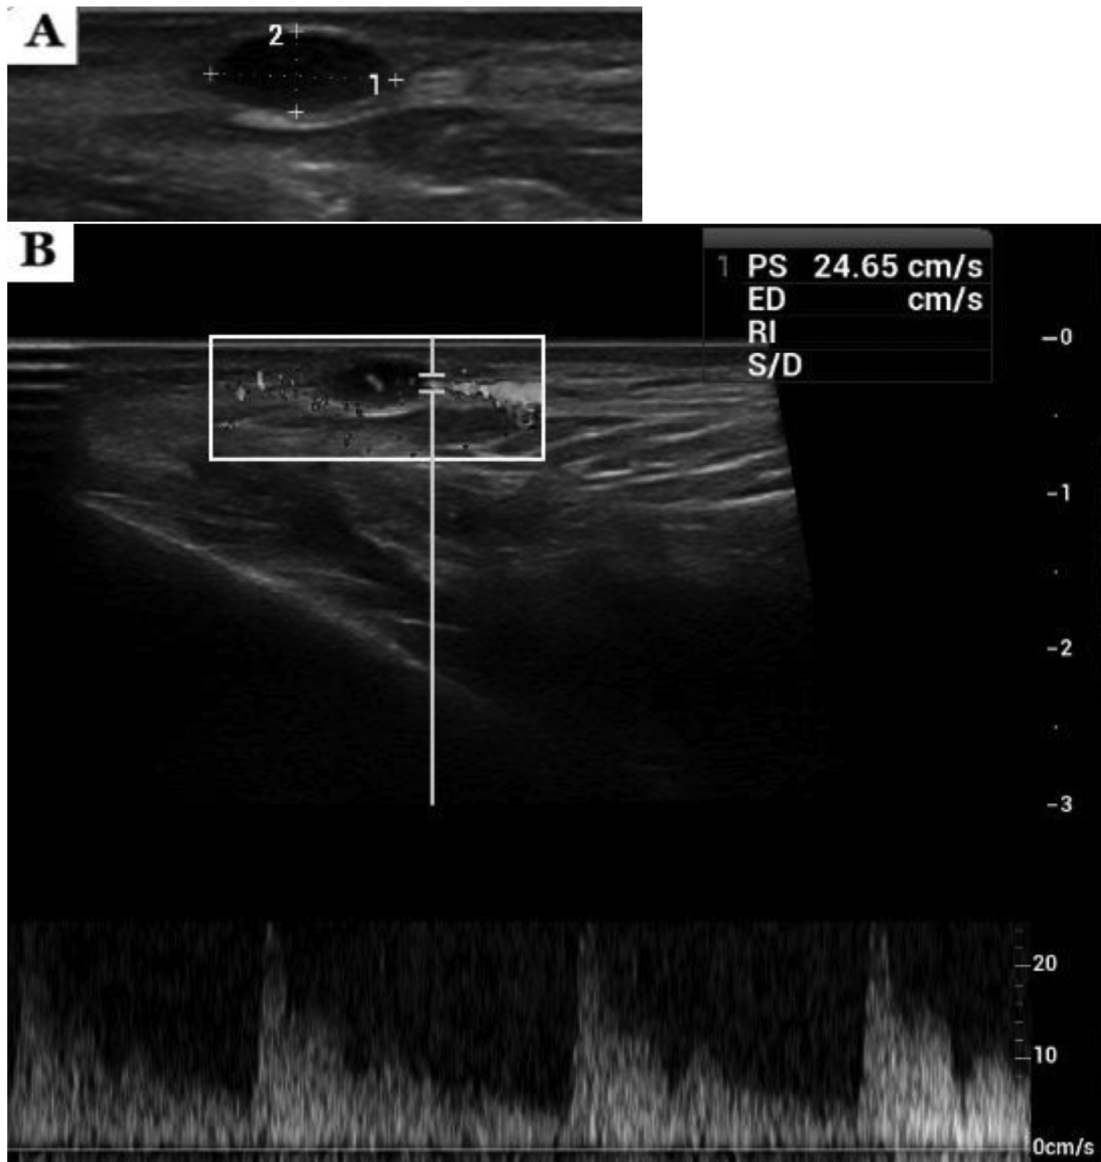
Follow-up ultrasound images, 3 months later. After conservative management the lesion size is decreased (A) but it is still vascular (B).
